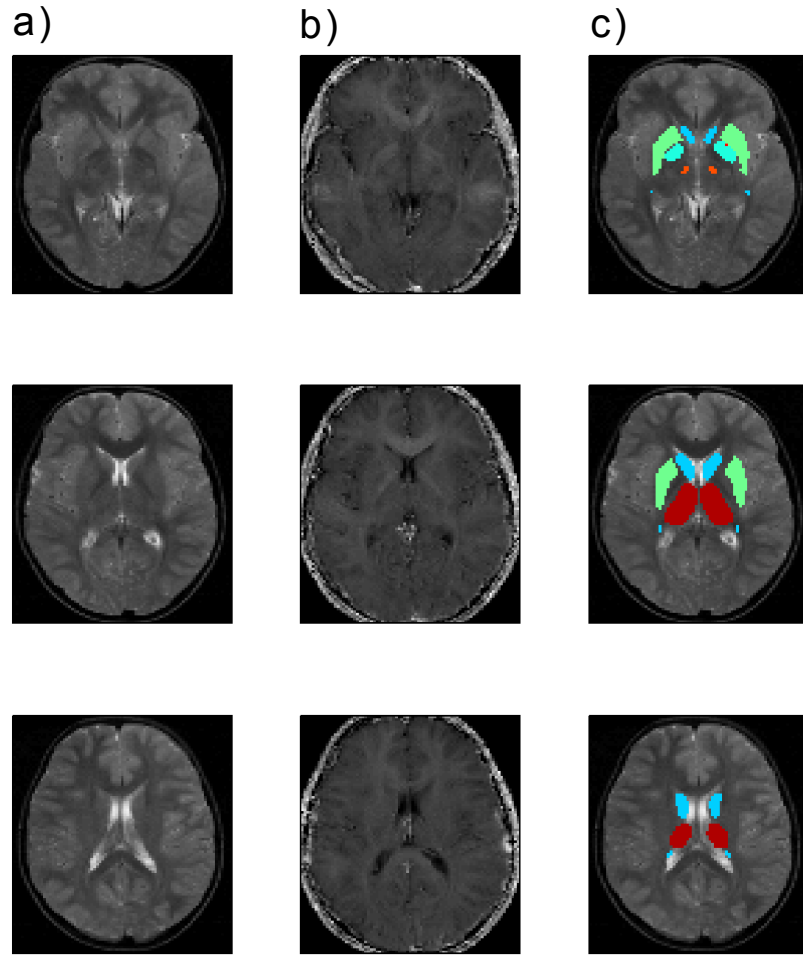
Three axial slices presenting, column-wise, in standard MNI space: a) T2-weighted images, b) R2 maps, and c) ROIs. The caudate is in blue, the globus pallidus in teal, the putamen in green, the substantia nigra in orange and the thalamus in red.
